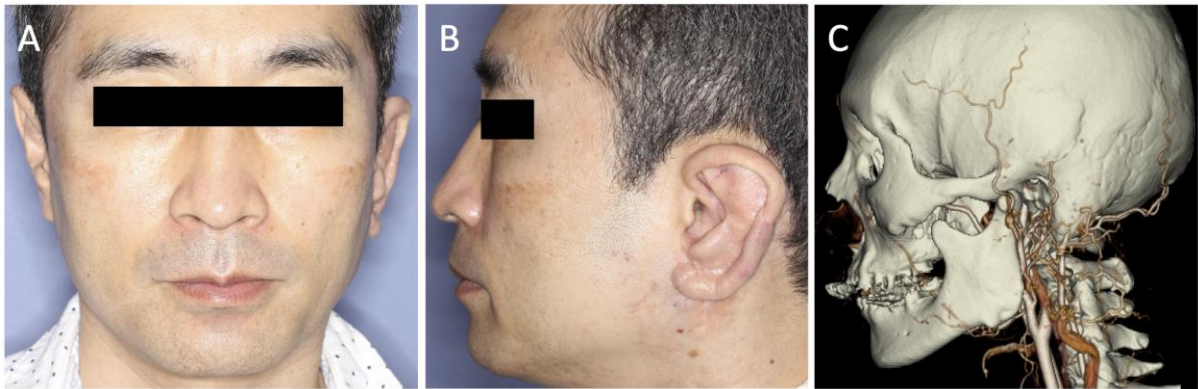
Findings at 6 months after the final operation. (A, B) Photographs show no recurrence with reduction of the enlarged left ear. (C) Enhanced computed tomography scans show reduction of most of the tortuous vessels in the external left ear with a dilated external jugular vein.
